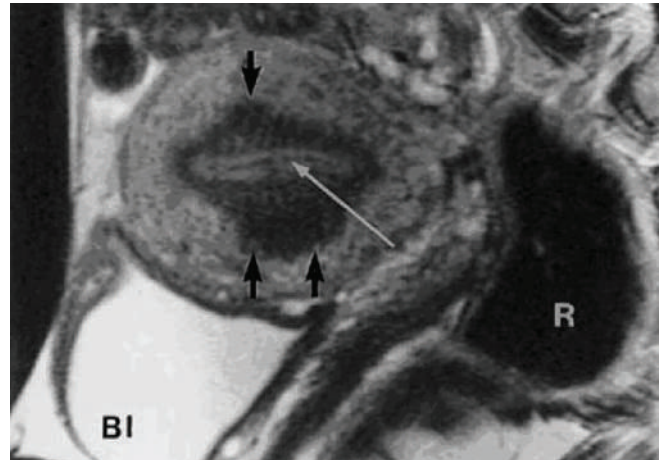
MRI showing adenomyosis with increased JZ thickness
